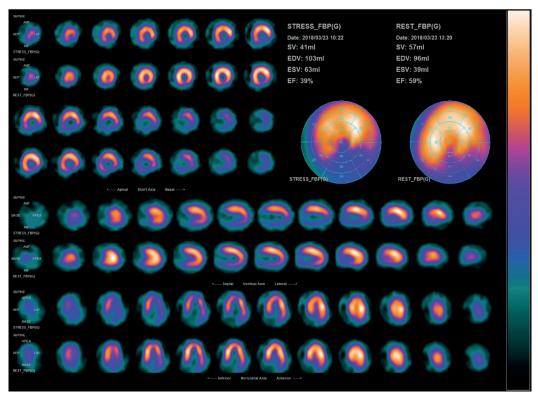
Patient 1 myocardial perfusion before ESMR therapy measured using SPECT scan.
